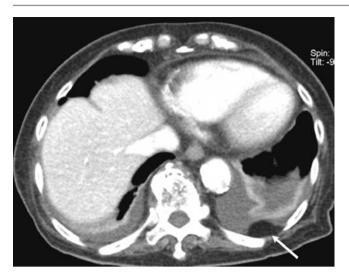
Axial CT image shows an incidental pleural lipoma
